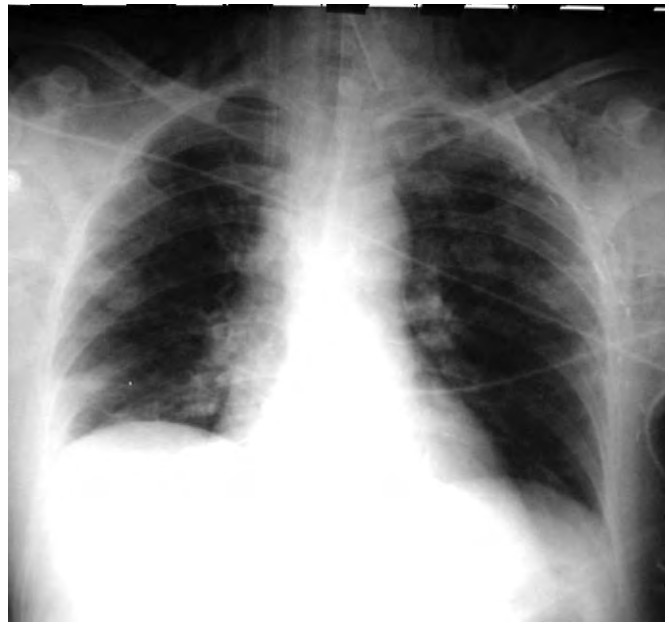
Chest radiograph of a patient with spontaneous thoracic esophageal perforation and subcutaneous emphysema.
